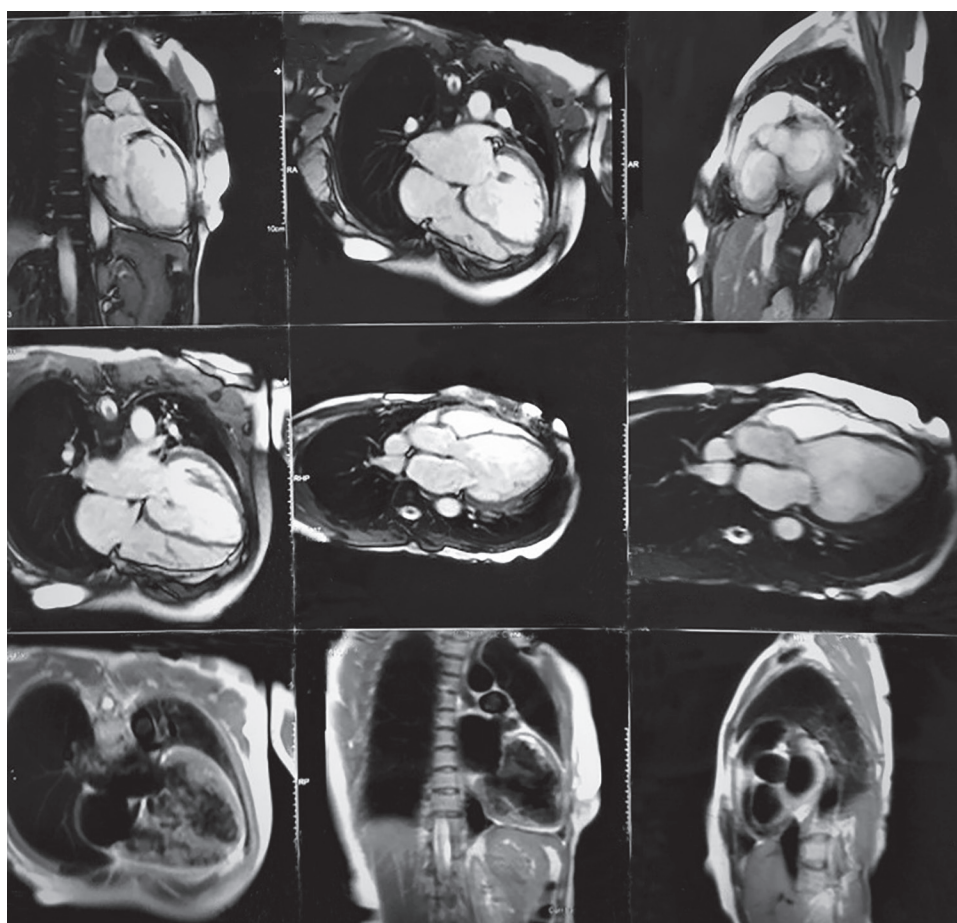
Cardiac MRI image
